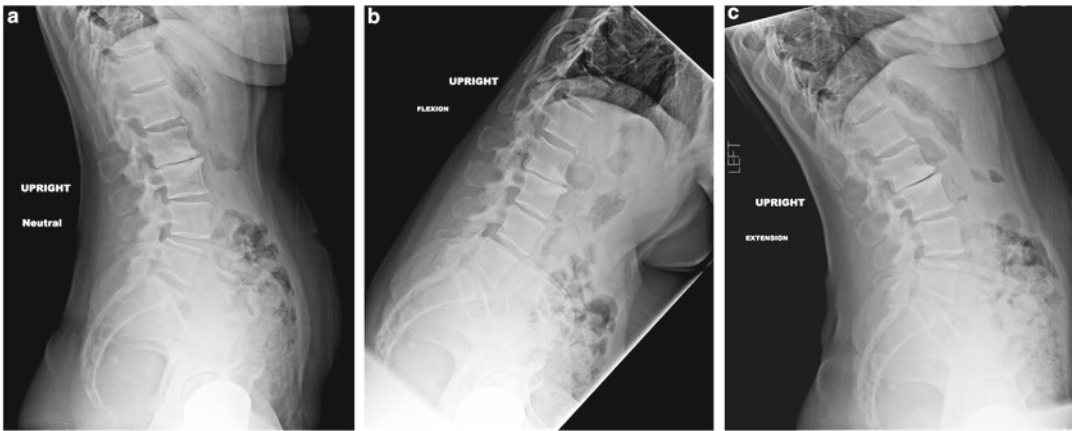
Grade 1 spondylolisthesis. Standing lateral neutral, flexion, and extension radiographs demonstrating the mobility of Grade 1 spondylolisthesis. (a) Standing neutral radiograph revealing a subtle Grade 1 spondylolisthesis. (b) Flexion study clearly demonstrating anterior translation of the L4 vertebral body on L5. (c) Extension
